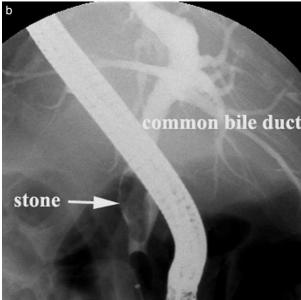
Large stone (diameter about 25 mm) at the common bile duct in ultrasound (US) (a) and endoscopic retrograde cholangiography (ERC) (b).
